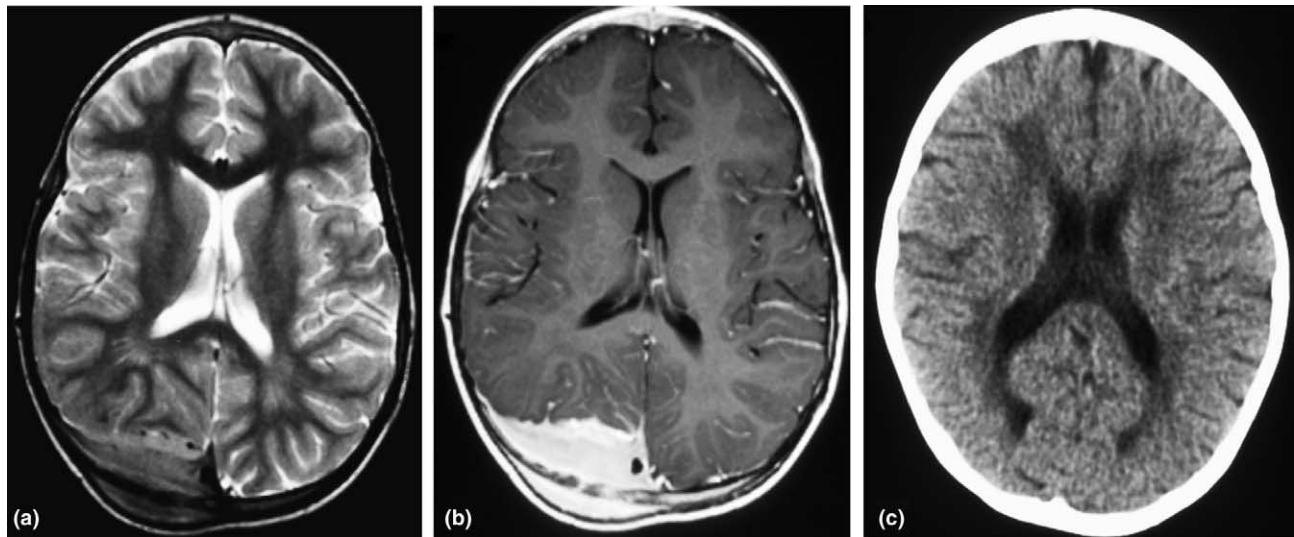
Case 2: 6-year-old girl with right occipital meningeal leukaemia. (a)/(b): T2- and T1-weighted MR images after contrast show an enhancing right occipital epidural mass with permeation of skull and extracerebral soft-tissue component. (c): CT scan after radiation and chemotherapy therapy shows no enhancement and the development of diffuse necrotising leucoencephalopathy.
